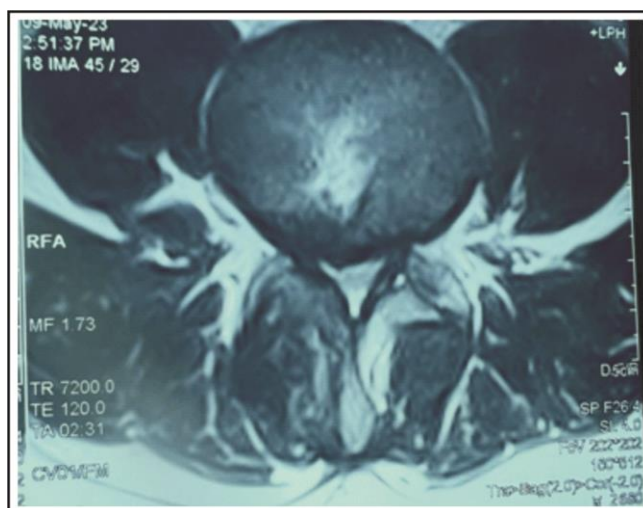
Post-operative MRI (Image included with patient consent).
